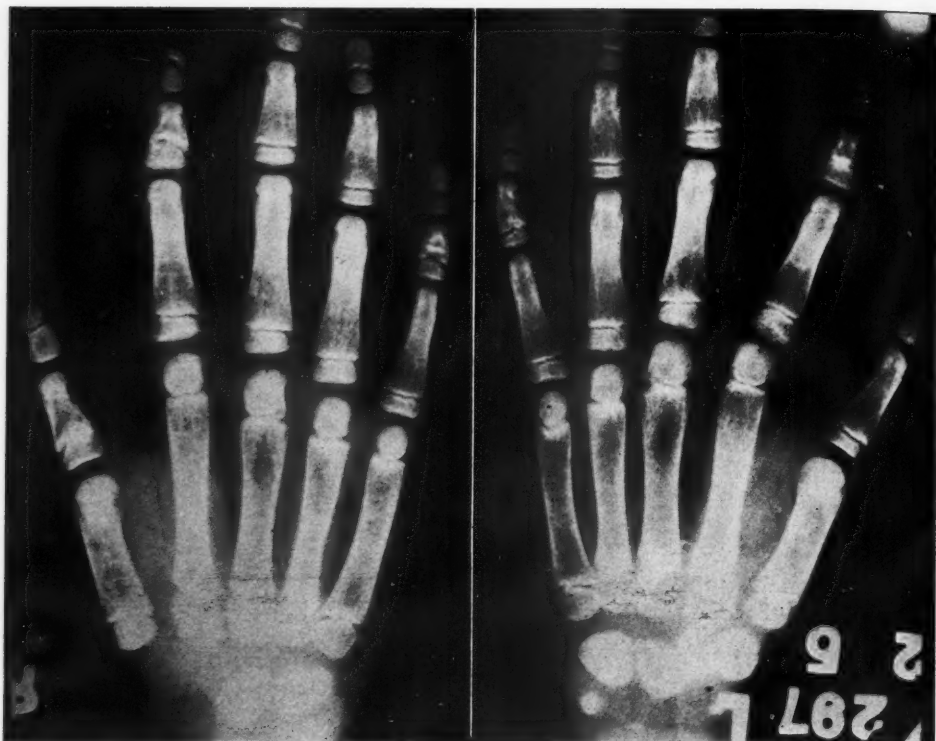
Roentgenogram of the hands. Note carpal development, double metacarpal epiphyses, and abortive epiphyses at the distal ends of the phalanges.
